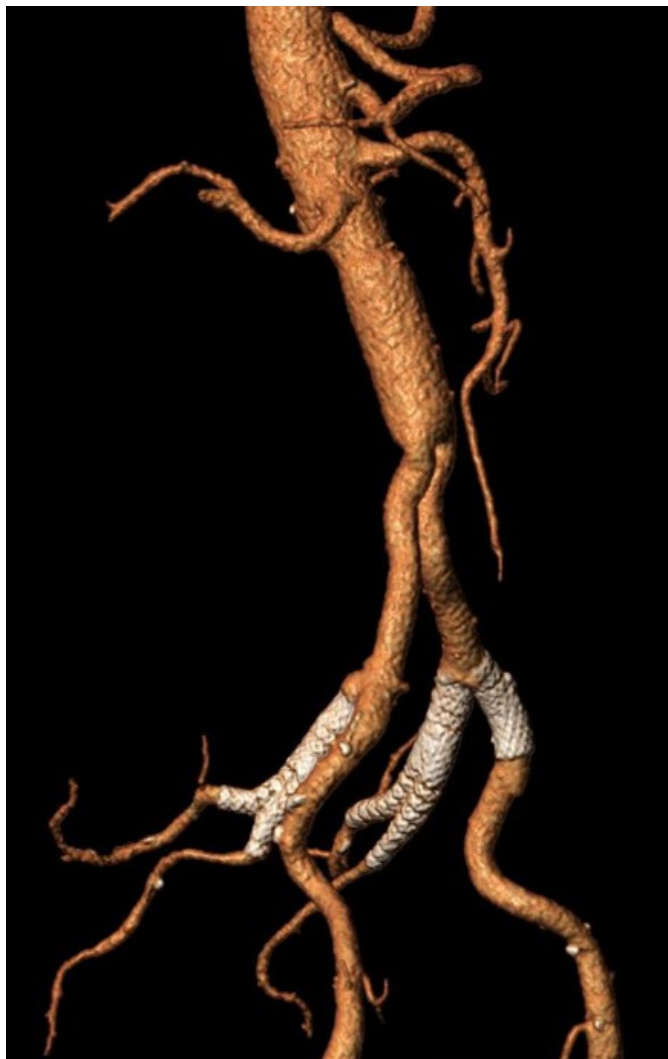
First month computed tomography angiography showing good patency of all balloon expandable covered stents in both sides without any endoleak.
